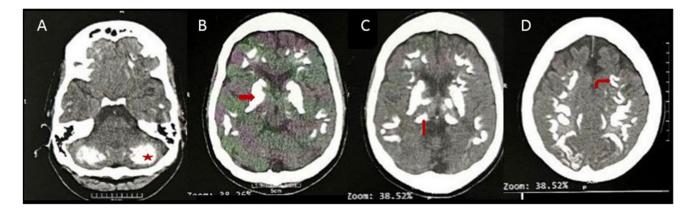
Brain CT scan of PFBC2-III1 case, showing calcification of dentate nuclei (A, red star), striatum (B, horizontal red arrow), thalami (C, vertical red arrow), and subcortical white matter (D, curved arrow)
